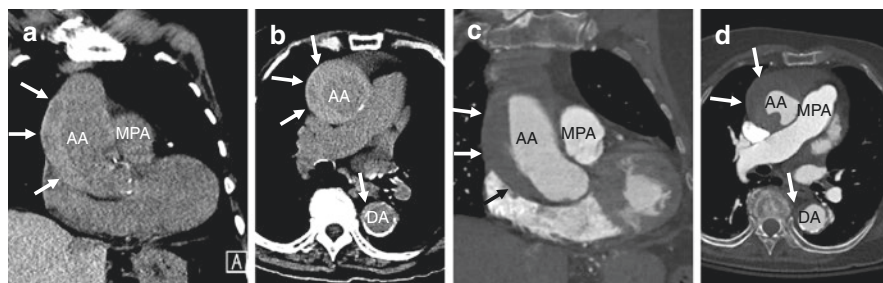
Noncontrast (a–b) and postcontrast contrast (c–d) coronal (a, c) and axial (b, d) CT images demonstrate a large type A IMH in a 97-year old woman with chest pain. Noncontrast images show the high-density crescent of IMH (arrows) that is even evident, but subtle, in the anteromedial descending aorta (DA) (b, d). As noted in the text section ‘Predictors of Outcome’, the maximal wall thickness of 17 mm and maximum ascending aortic diameters of 56 mm seen in this case would generally be considered high risk features of IMH. AA ascending aorta; DA descending aorta; MPA main pulmonary artery
